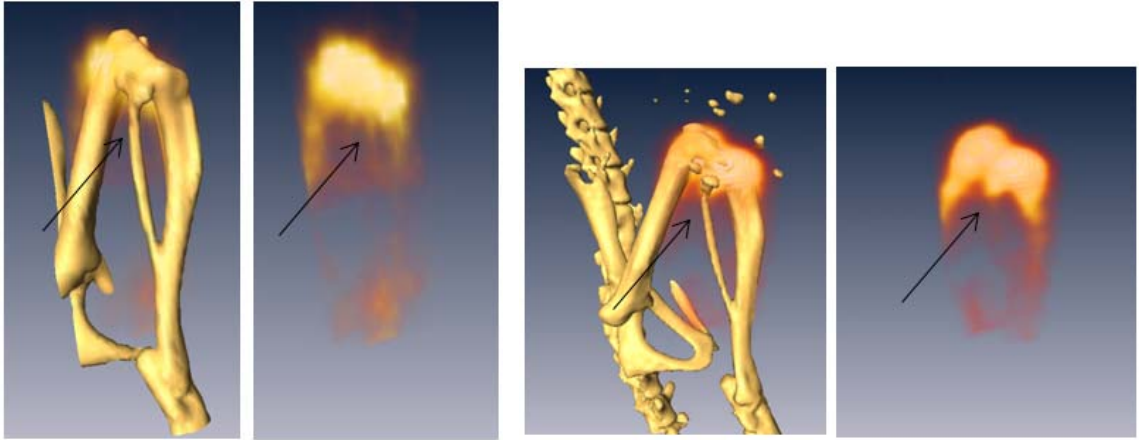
Panel a shows a close up view of PET image with and without CT and panel b shows SPECT images with and without CT. Arrows indicate region where fibula is present.
